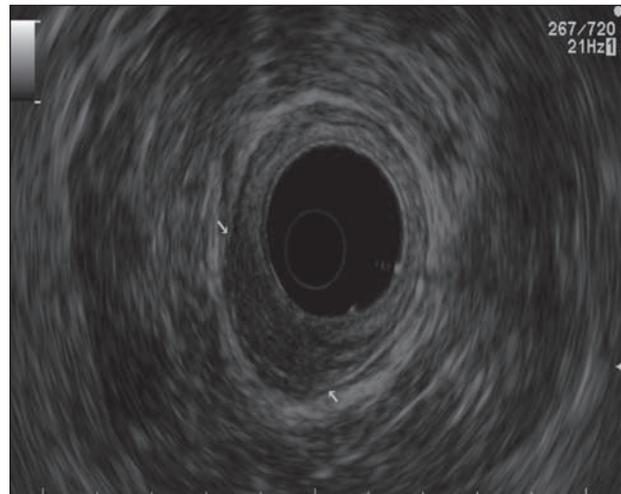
Endoscopic ultrasound showing hypoechoic and thickened submucosal layer in the upper anal canal
